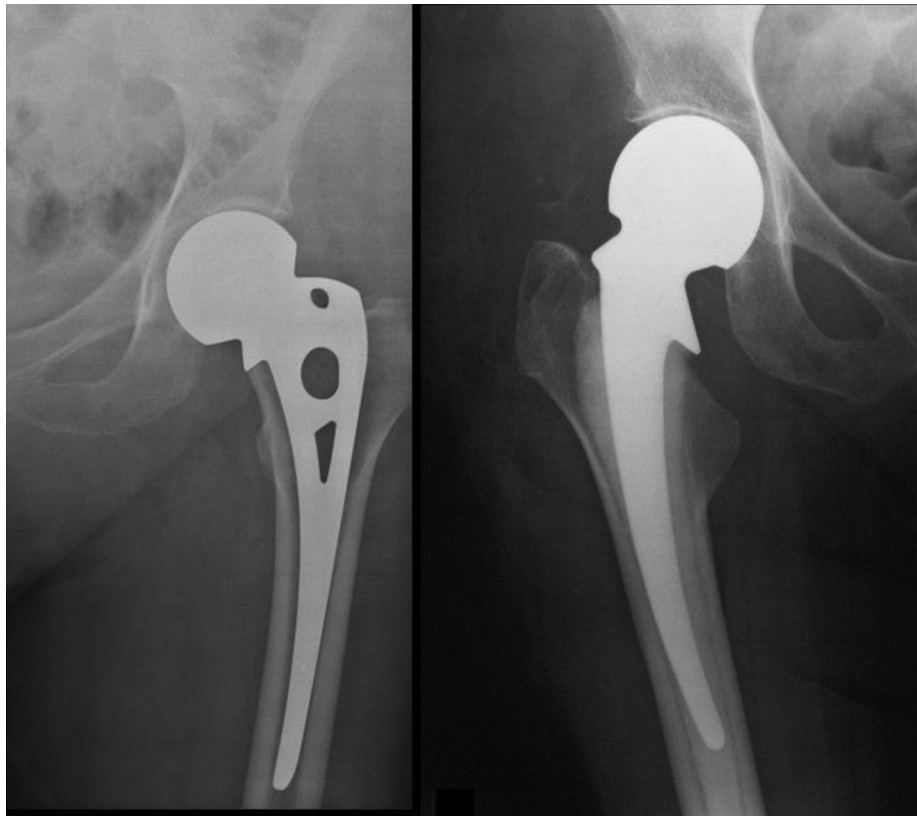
Post-operative clinical radiographs showing an uncemented Austin-Moore Prosthesis (left), and a cemented Thompson Prosthesis (right).
